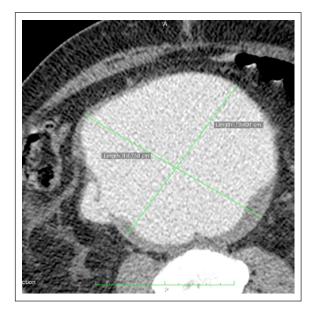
CTA demonstrated a 140-mm rAAA, with aortocaval fistula.
